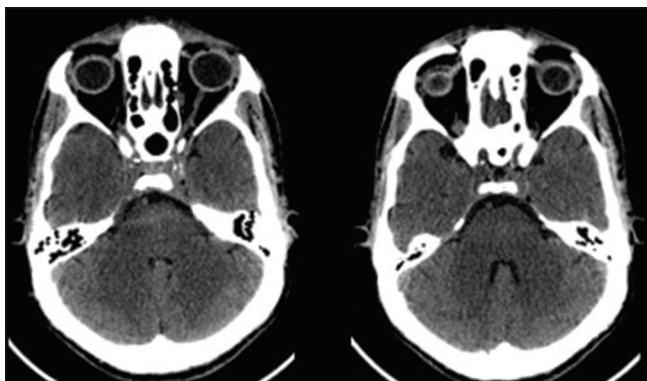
Axial sections of CT show no infarct or haemorrhage in cerebellar hemispheres
